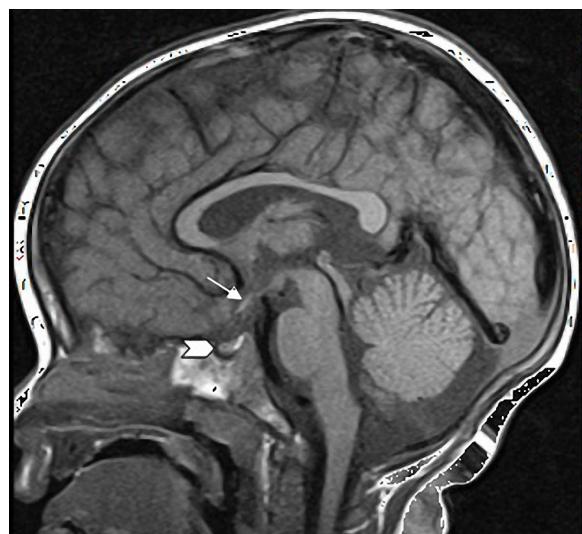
Sagittal T1 weighted MRI image showing normal appearance of pituitary gland and position of posterior pituitary bright spot (arrowhead). The corpus callosum appears fully formed. The optic chiasm (arrow) is slightly thin.
